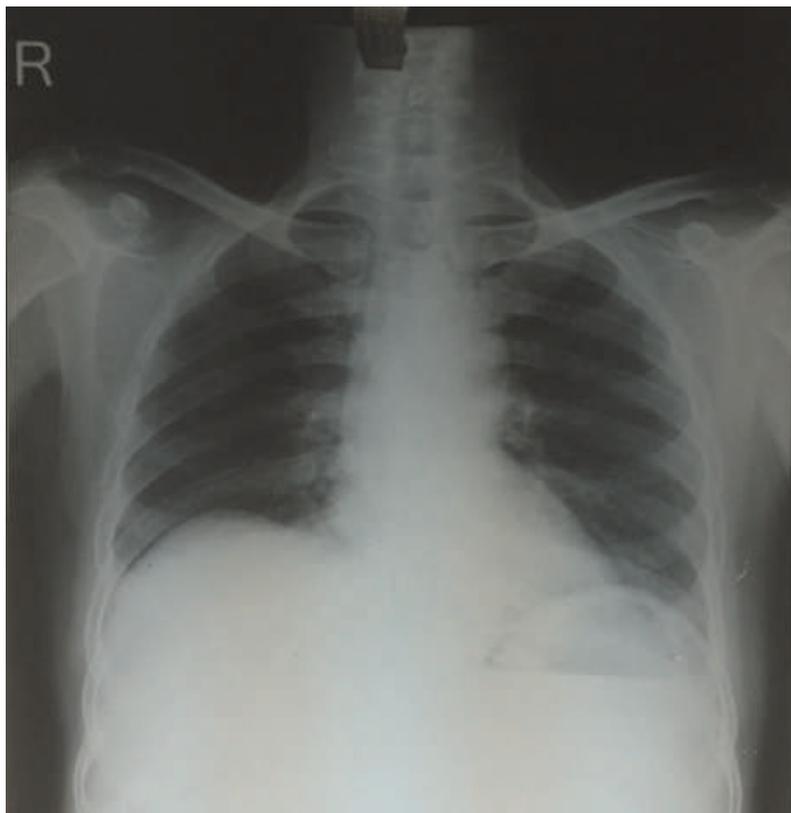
Chest X-ray PA view showing no pulmonary involvement.
